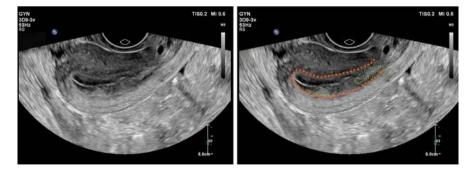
Multiple endometrial polyps are observed with a thickened endometrium and uneven echogenicity on ultrasound. The uterine cavity is circled in orange; the polyps are circled in green
